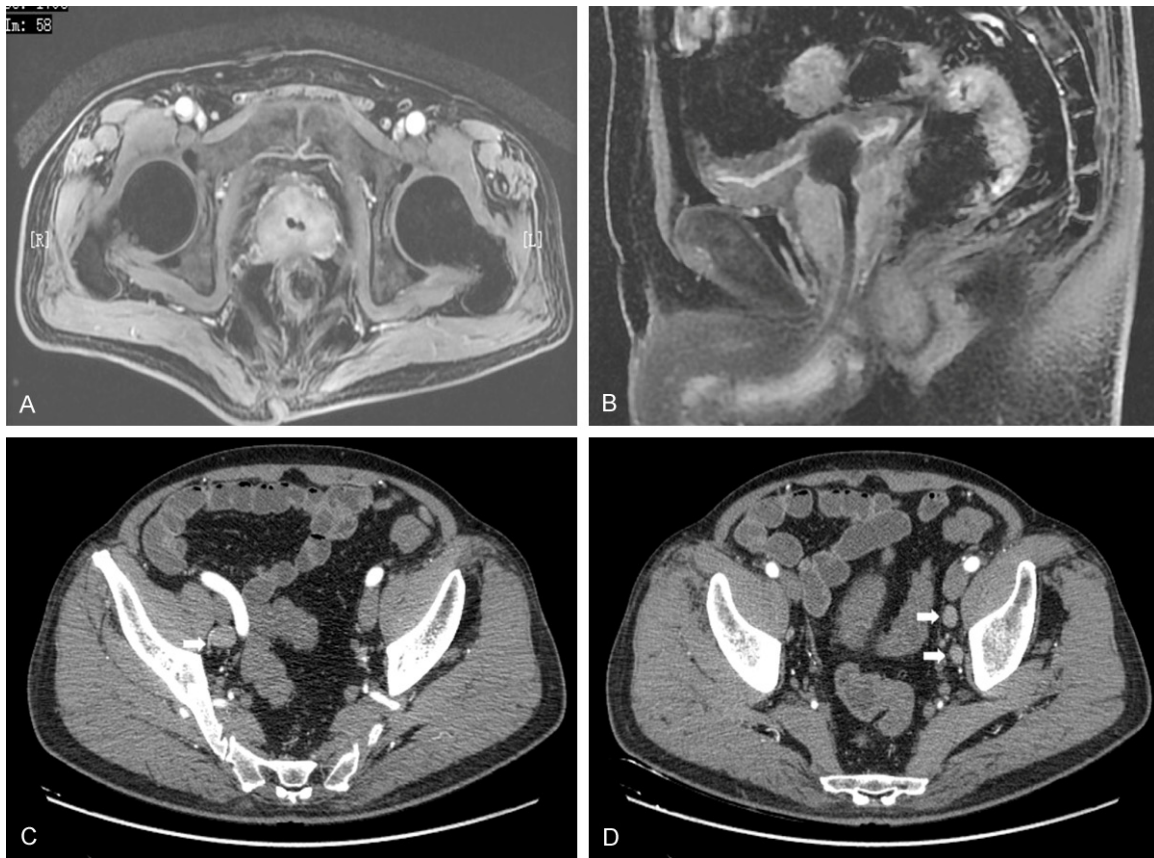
Abdominal magnetic resonance imaging revealed an enlarged prostate and the heterogenous enhancement on fat-suppressed contrast-enhanced T1-weighted imaging (A, B). Abdominal computed tomography showed multiple lymphadenopathy (arrow) whose sizes were approximately 1.2-1.8 cm (C, D).
